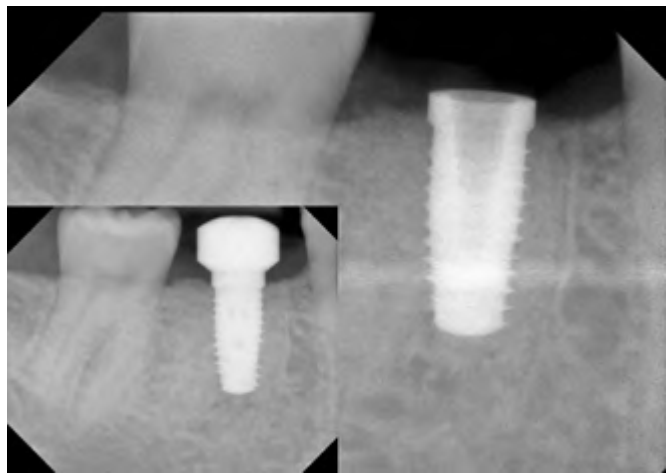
Radiograph taken at the time of implant placement. The implant was placed approximately 1 mm supracrestal. The inset (lower left) demonstrates that the healing abutment was accurately seated at the time of implant placement.
